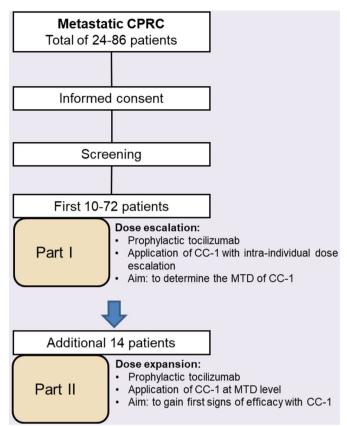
Study overview. CC-1, bispecific PSMAxCD3 antibody; CRPC, castration-resistant prostate carcinoma; MTD, maximum tolerated dose.
